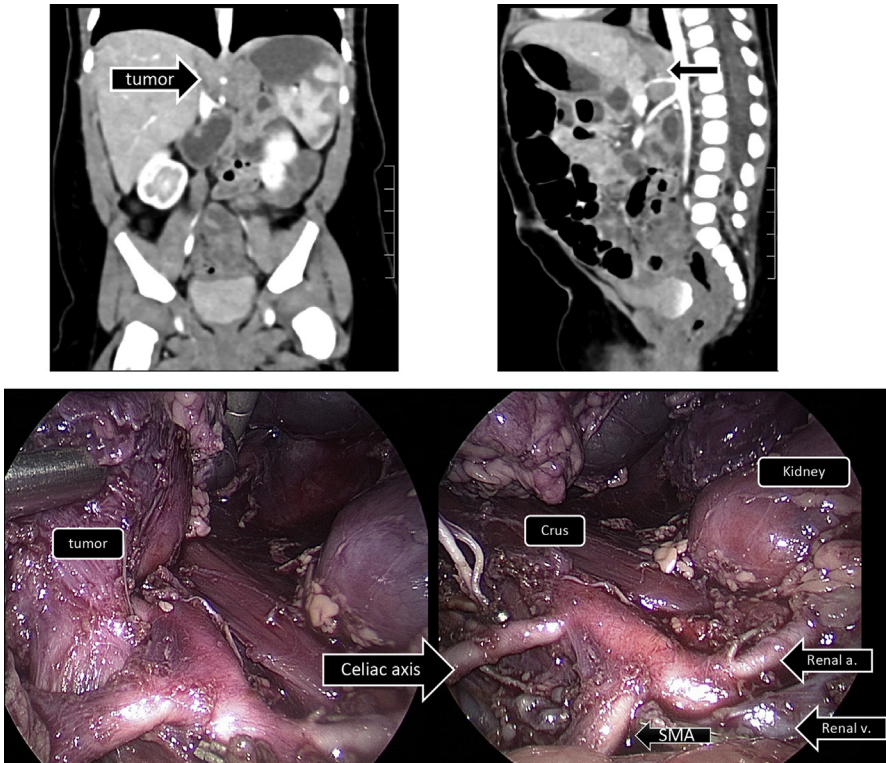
Neuroblastoma with an image-defined risk factor (L2, encasement of the celiac axis) shown on coronal (*top, left*) and sagittal (*top, right*) views of the preoperative computed tomography scan. Laparoscopic mobilization of the tumor (*bottom, left*) and resection bed (*bottom, right*). (Courtesy of Harold N. Lovvorn, III, M.D.)
